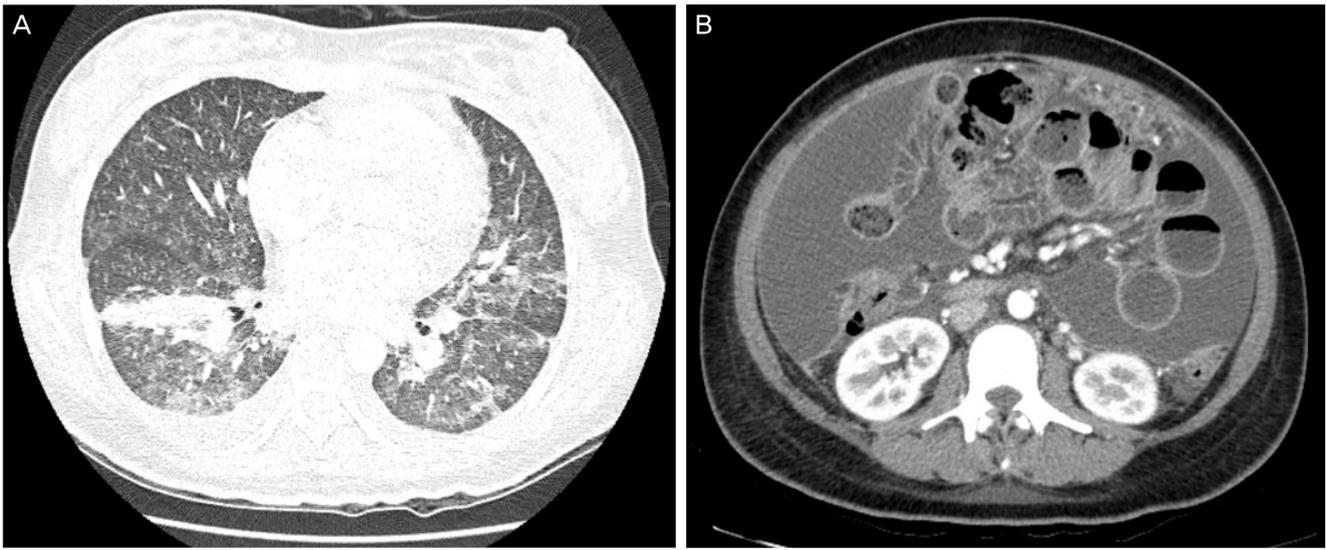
(A) Chest computed tomography image showing diffuse miliary nodules and ground glass opacity patterns in both lungs. (B) An abdominopelvic computed tomography image showing large amount of ascites and omental fatty infiltration.
